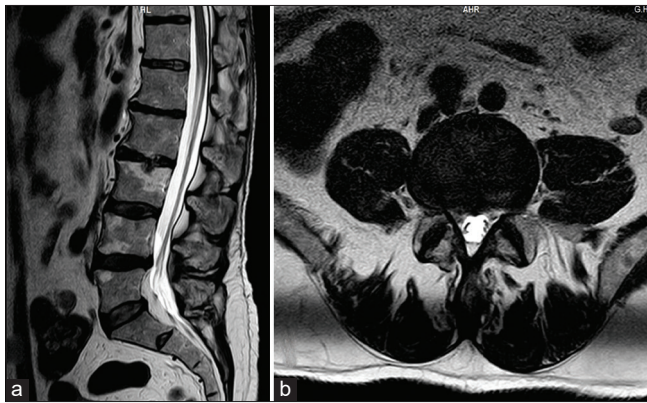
Preoperative (a) sagittal and (b) transverse magnetic resonance imaging analysis, demonstrating the presence of lumbar disc herniation in the L4-L5 level.
